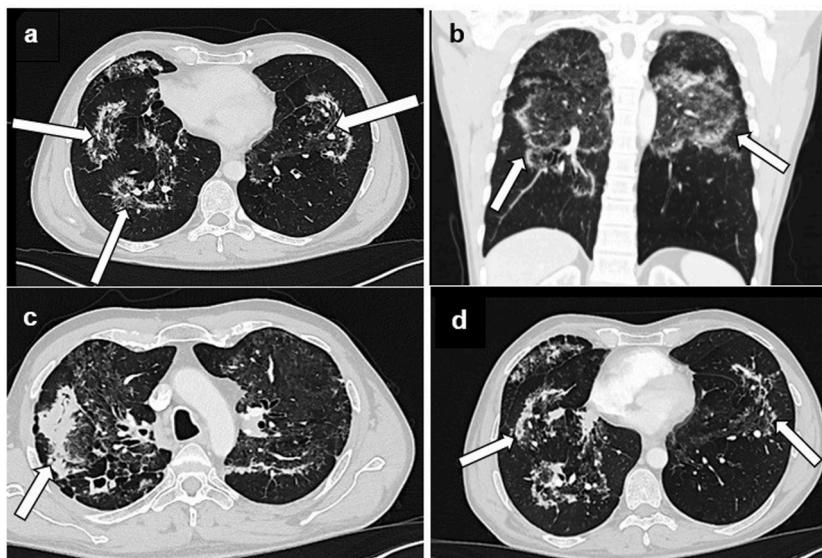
Chest CT scans of patient number 2. Axial (a) and coronal (b) planes show rounded areas of ground-glass opacities surrounded by a complete ring of consolidation (reversed halo signs, arrows) in the upper lobes. No lymphadenopathy is seen. A follow up HRCT scan, two months following the treatment starting point. Multiple cavitations, cluster signs (c) and RHS (d) are present in both upper lobes, however more prominent on the right.
